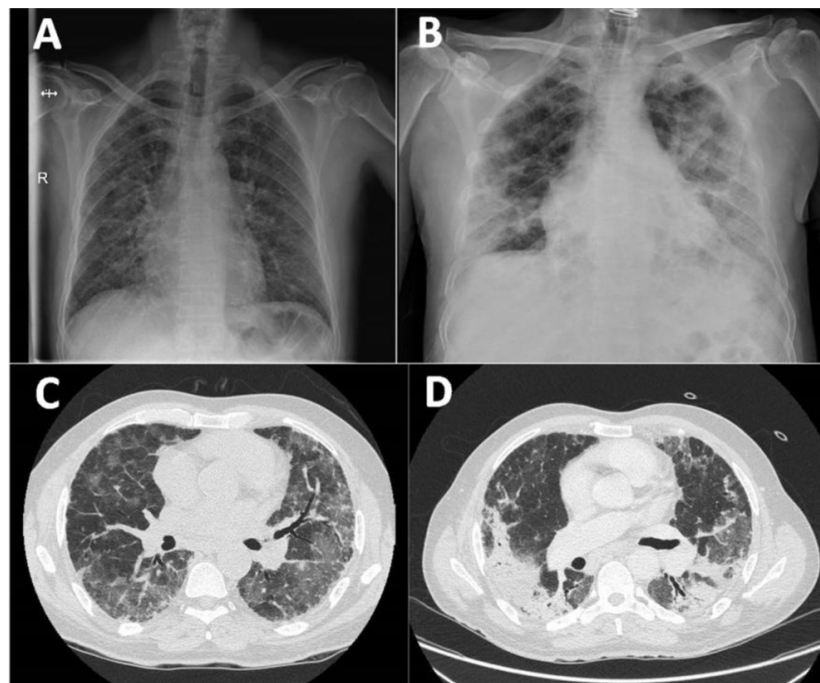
(A) Initial chest X-ray with faint bilateral interstitial infiltrates with respect to costophrenic sinuses. (B) Chest X-ray on arrival at the intensive care unit showing increased persistent interstitial infiltrates bilaterally more accentuated at peripheral level with associated alveolar pattern. (C) Chest CT showed a crazy paving pattern initially with foci of incipient consolidation. (D) Chest CT performed after discharge from the intensive care unit showed radiological worsening with areas of consolidation in both upper and lower fields, in addition to presenting a cobblestone pattern and tarnished glass.
